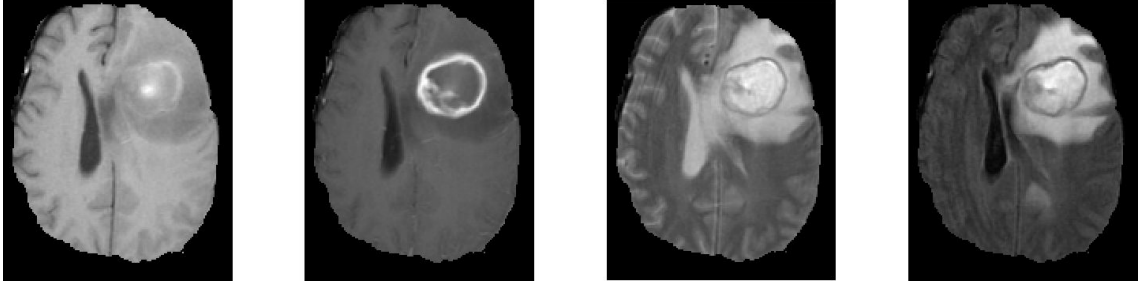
From left to right: T1, T1C, T2 and FLAIR images of the same slice.
